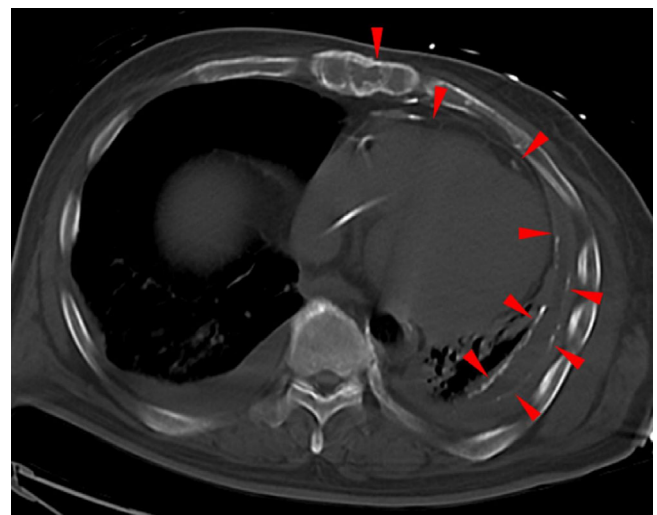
Computed tomography findings on admission. Severe ossification of the left costal cartilage and sternum (red triangle head) was revealed
